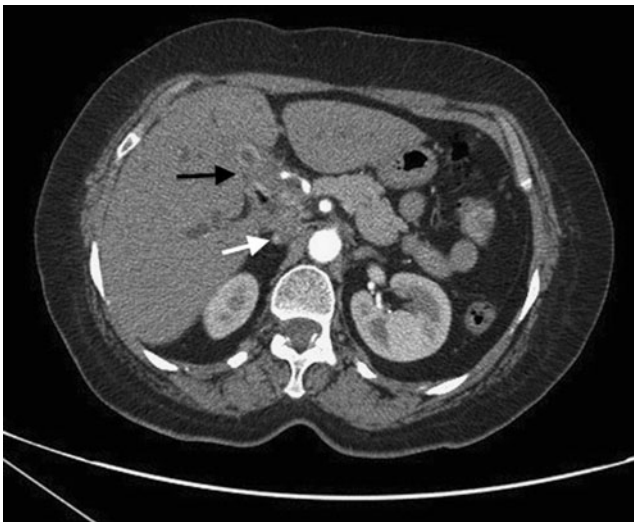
Computed tomography scan—showing a mass in the gallbladder (*black arrow*) with associated lymphadenopathy (*white arrow*) in a patient with gallbladder tuberculosis
